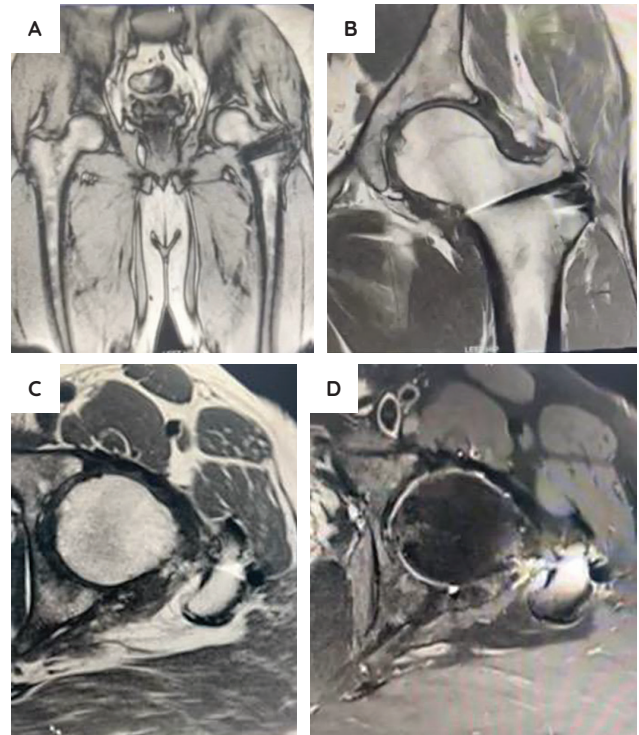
T1-weighted MRI of the pelvis showing no lysis of the left femoral head or the fixation over the greater trochanter: coronal (A) and sagittal (B) views taken 1 year post-op; axial cuts (C and D) similarly demonstrate no evidence of lysis at 1 year postop.
